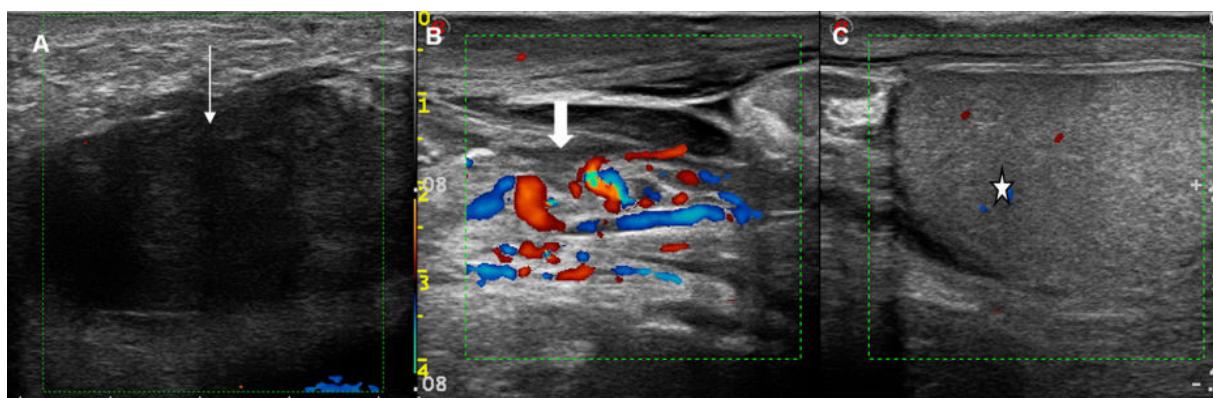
(A) Acute torsion: Hypoechoic testis with completely absent vascularity on color Doppler (thin arrow). (B,C) Split screen color Doppler US shows “Whirl pool” sign of testicular torsion due to the twisting of spermatic cord (thick arrow) and avascular testis (*).
